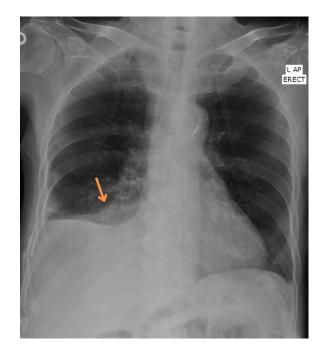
Anteroposterior chest radiograph during outpatient visit showing lobulated opacity with spiculated margin in the right lower lobe (orange arrow) and increasing right pleural effusion.
